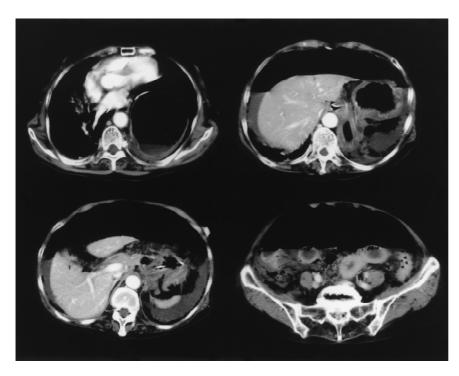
Abdominal computed tomography revealing intraperitoneal free air, ascites, and the stomach prolapsing into the left thorax
